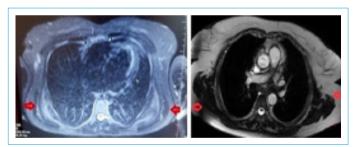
MRI images of ED.
